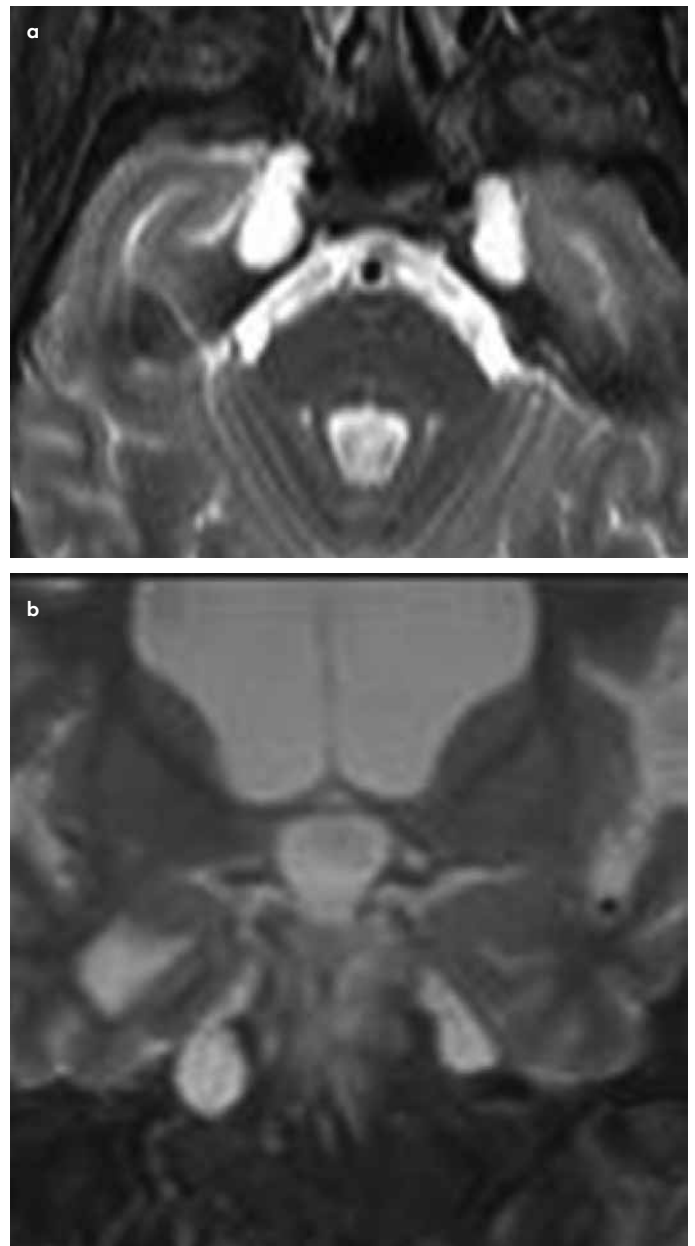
a, b. Petrous apex cephalocele. Axial and coronal T2-weighted images show bilateral, well-defined CSF isointense lesion extending into the petrous apex from the region of the Meckel's cave.
